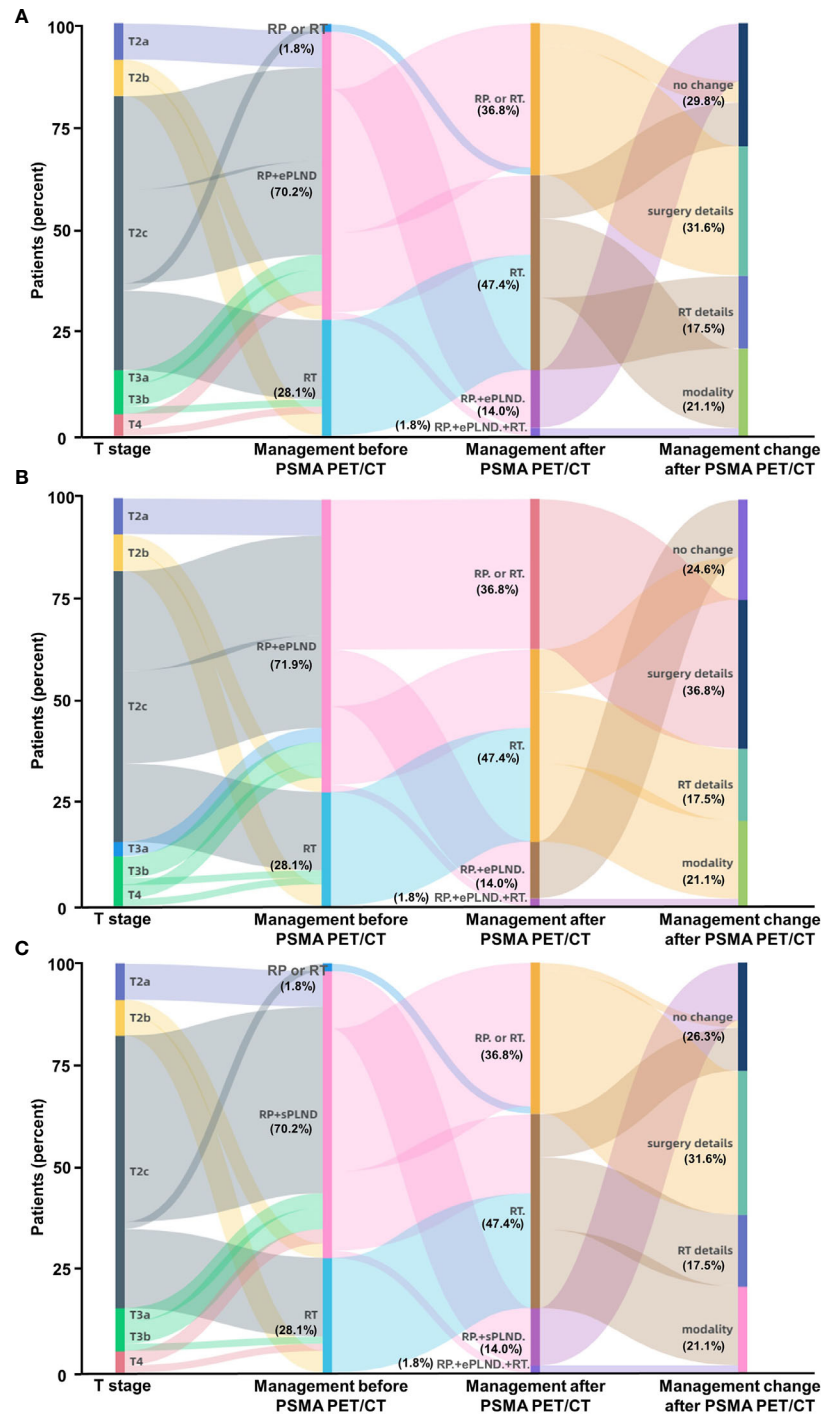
Impact of ^{68}Ga -PSMA PET/CT on clinical decision-making in high-risk treatment-naïve prostate cancer patients. (A) According to the Briganti nomogram, ^{68}Ga -PSMA PET/CT would have led changes of planned therapy in 70.2% of these patients and avoided unnecessary ePLND in 12.3% of the patients who have previously undetected non-regional LNMs. (B) According to the MSKCC nomogram, ^{68}Ga -PSMA PET/CT would have led changes of planned therapy in 75.4% of the patients; (C) According to the Winter nomogram, ^{68}Ga -PSMA PET/CT would have led changes of planned therapy in 73.7% of the patients. As the basic treatment for nearly all high-risk PC patients, ADT or systemic therapy was not included. (Modality: changes of therapy modality; surgery details: changes in surgery details; RT details: change in RT field; RP: radical prostatectomy; RT: radiotherapy; ePLND: extend PLND; sPLND: sentinel PLND).
